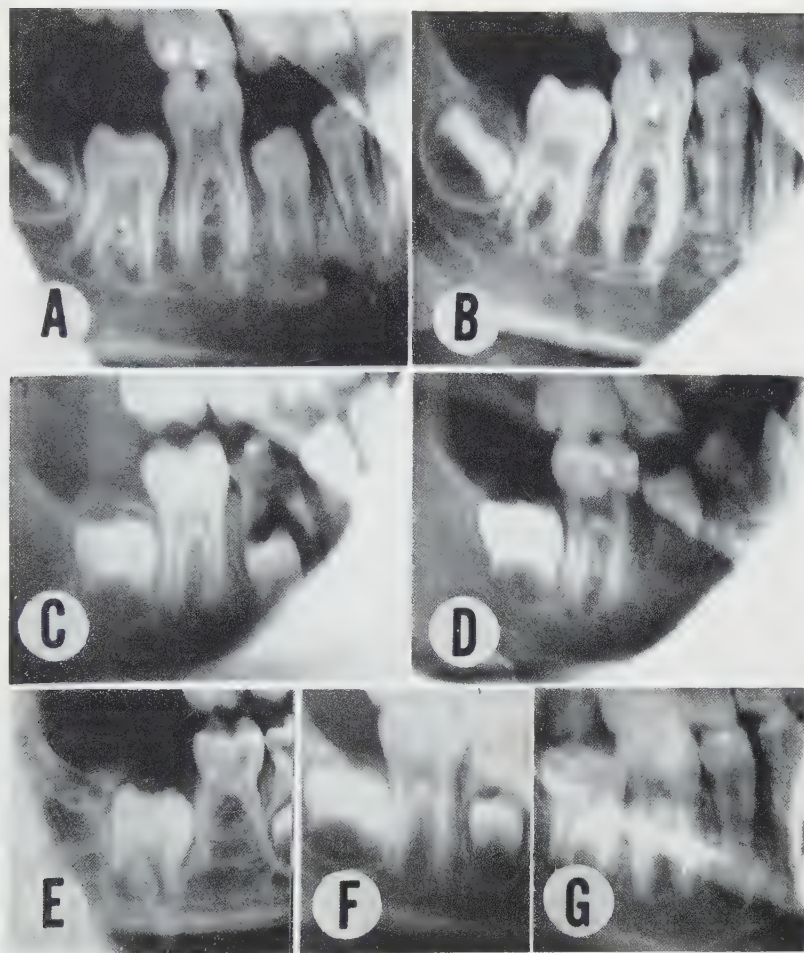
Roentgenograms showing variations in sequence during calcification and eruption. A and B: change from the ( $P_2M_2$ ) sequence in alveolar eruption at 11 years to the  $P_2M_2$  sequence in attaining the occlusal level at 12 years (Fels case No. 260). C and D: differential rates of travel of  $P_2$  and  $M_2$  between 8-1/2 and 9 years. In six months the deciduous predecessor of  $P_2$  has been shed and the crown of  $P_2$  has passed beyond clinical eruption, yet the level of  $M_2$  has changed but little (case No. 329). E, F and G: changes in sequence from  $M_2P_2$  in early crown calcification at 8-1/2 years to  $P_2M_2$  at the attainment of the occlusal level at 11-1/2 years (case No. 211).
